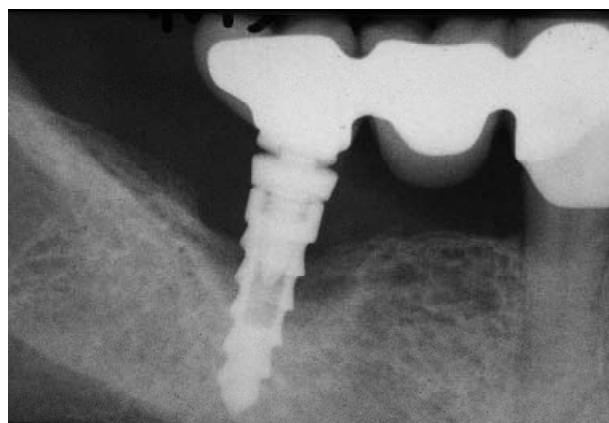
Preoperative X-ray of case 3 from Table 1.
